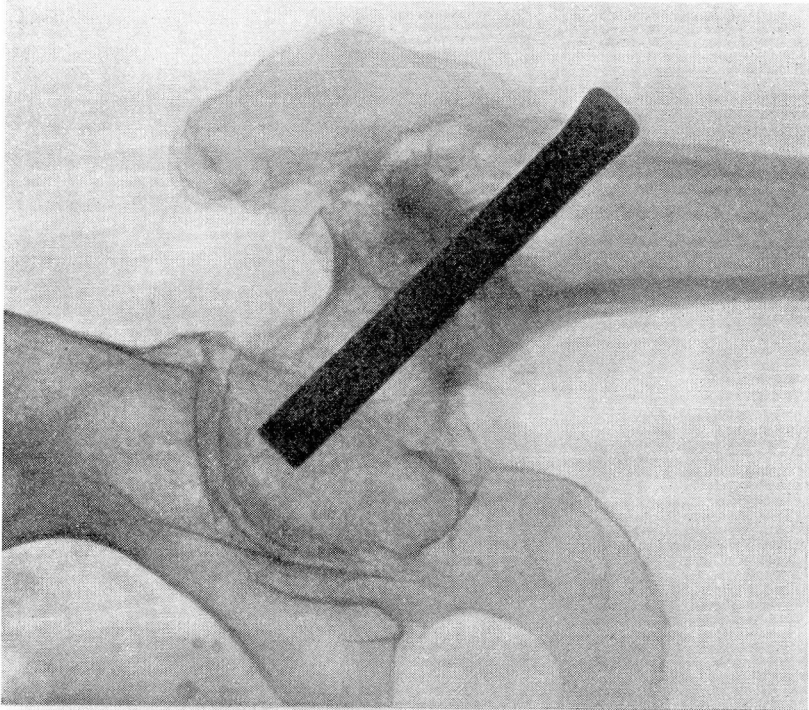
Case 2. Roentgenogram showing result 12 weeks after operation.
